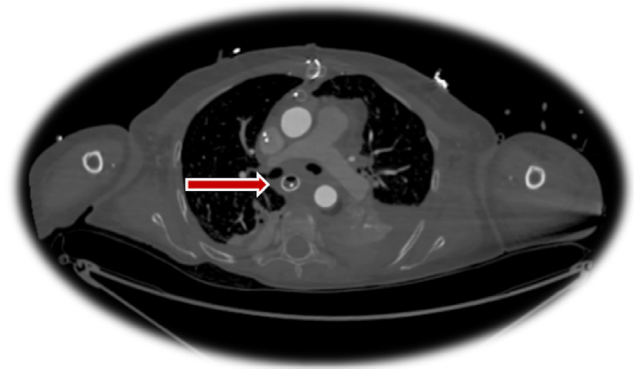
On the CTA taken after the third operation, an arrow shows the esophageal stent inserted at the beginning of the operation to cover the two perforations in the esophagus
